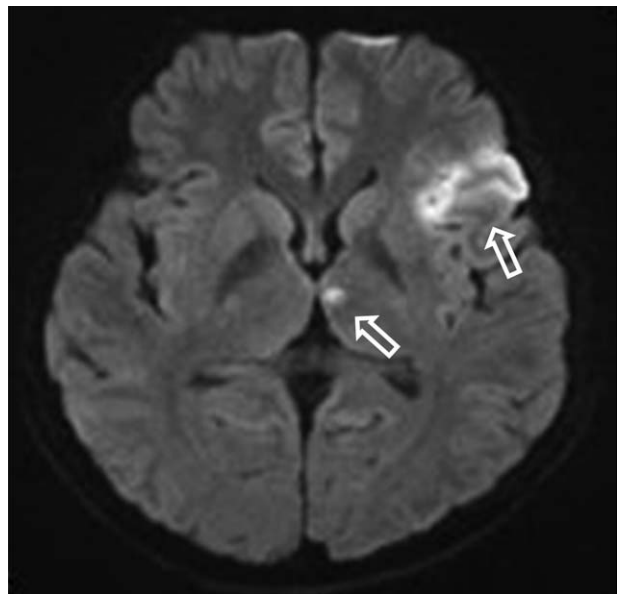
Brain magnetic resonance imaging was performed in the acute phase at 18 hours after the initial presentation of symptoms. Diffusion-weighted images (DWI TR/TE 4700/70) showed high signal intensity near the inferior frontal gyrus of the left frontal lobe and the left thalamus (white arrow), indicating acute infarction.
